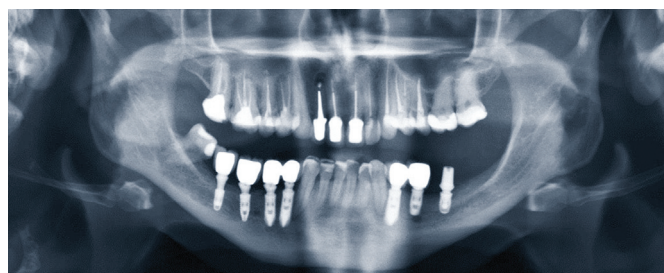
Panoramic radiograph taken when the patient was diagnosed with occlusal dysaesthesia.
